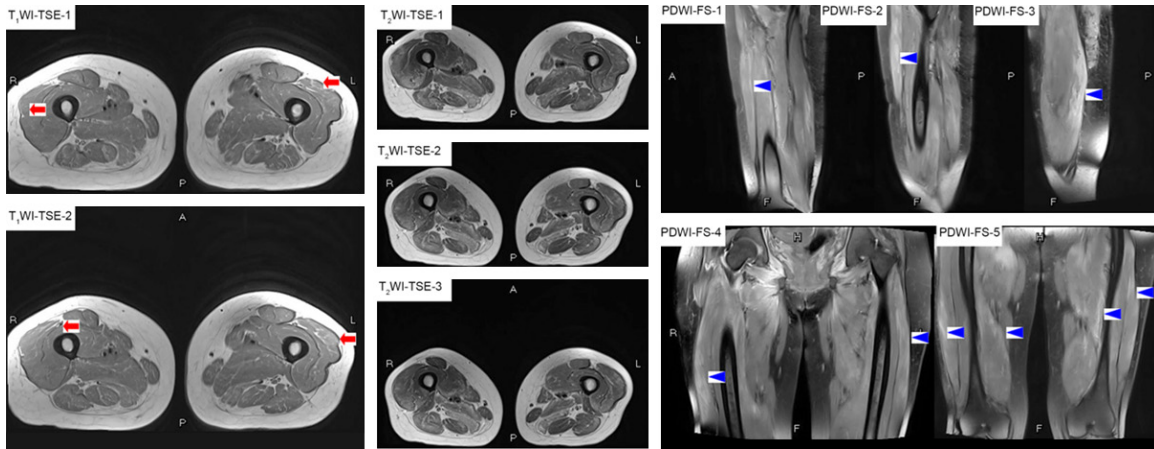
MRI of the bilateral thigh. (T_1 WI-TSE 1-2), vastus lateralis muscle shows abnormal signal intensity on the T_1 WI-TSE image, suggesting mild atrophy and fat infiltration (arrows). (T_2 WI-TSE 1-3), semimembranosus and vastus lateralis muscle shows high signal intensity on the T_2 WI-TSE image, suggesting muscle edema. (PDWI-FS 1-5) semimembranosus and vastus lateralis muscle shows high signal intensity on the PDWI-FS image, suggesting muscle edema (arrowheads).
